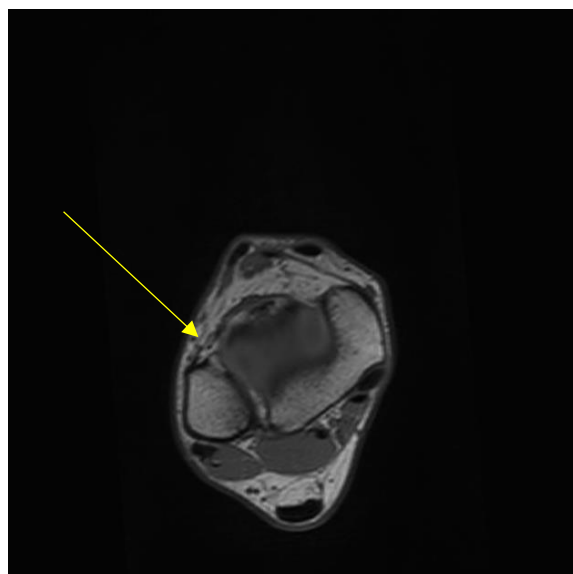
Ankle MRI, with the evidence of an APA injurie
